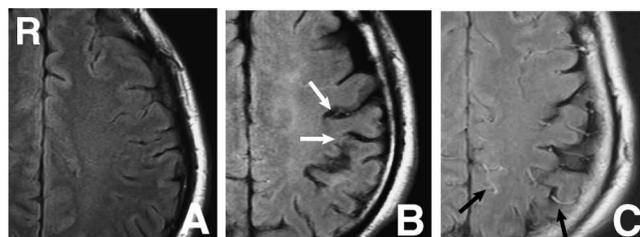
A: Moyamoya disease in a 36-year-old male. Transverse fluid-attenuated inversion recovery (FLAIR) image showing no ivy patterns in leptomeninges ("absent"). B: Moyamoya disease in a 44-year-old male. Transverse FLAIR image showing iso-intense ivy patterns (arrows) in leptomeninges. C: Moyamoya disease in a 32-year-old female. Transverse FLAIR image revealing multiple areas of high signal intensity (arrows) in leptomeninges.
